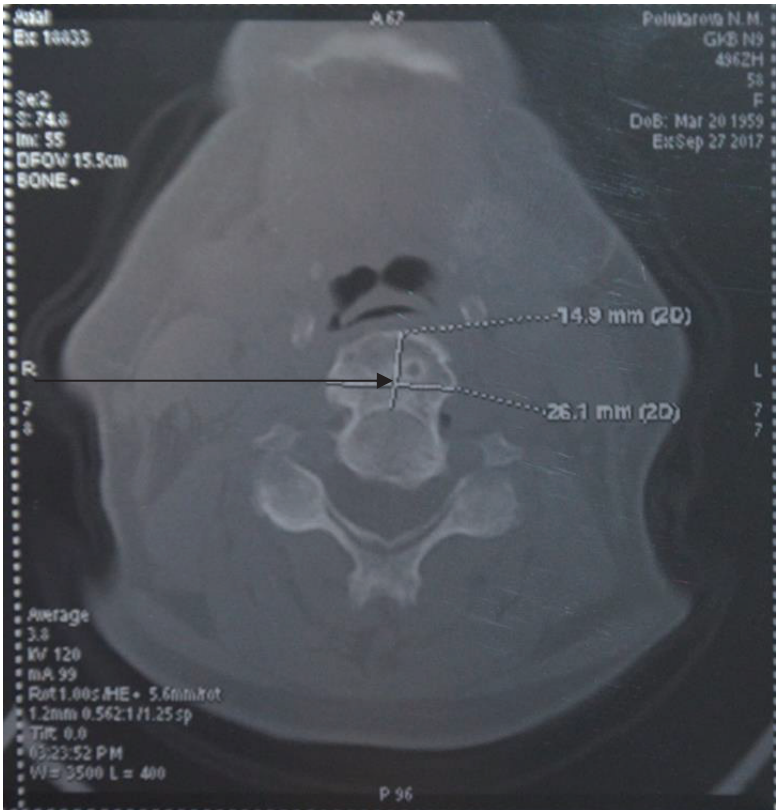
Computed tomography of the cervical spine, axial view. The arrow indicates the ossification of the anterior longitudinal ligament on the anterior surface of the vertebral body measuring 14.9 × 26.1 mm
